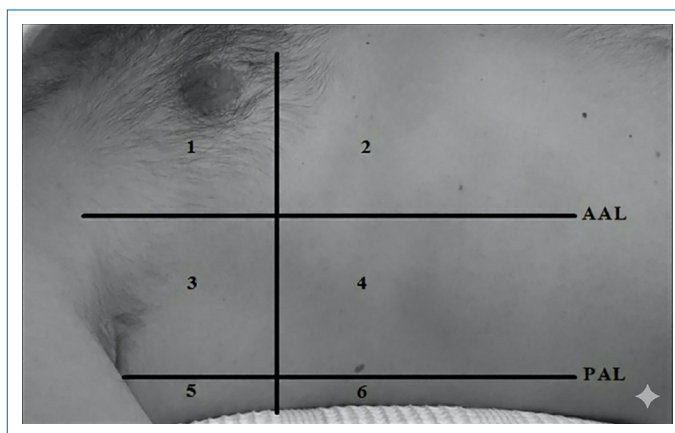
Standardised 12-zone lung ultrasound scanning zones.
